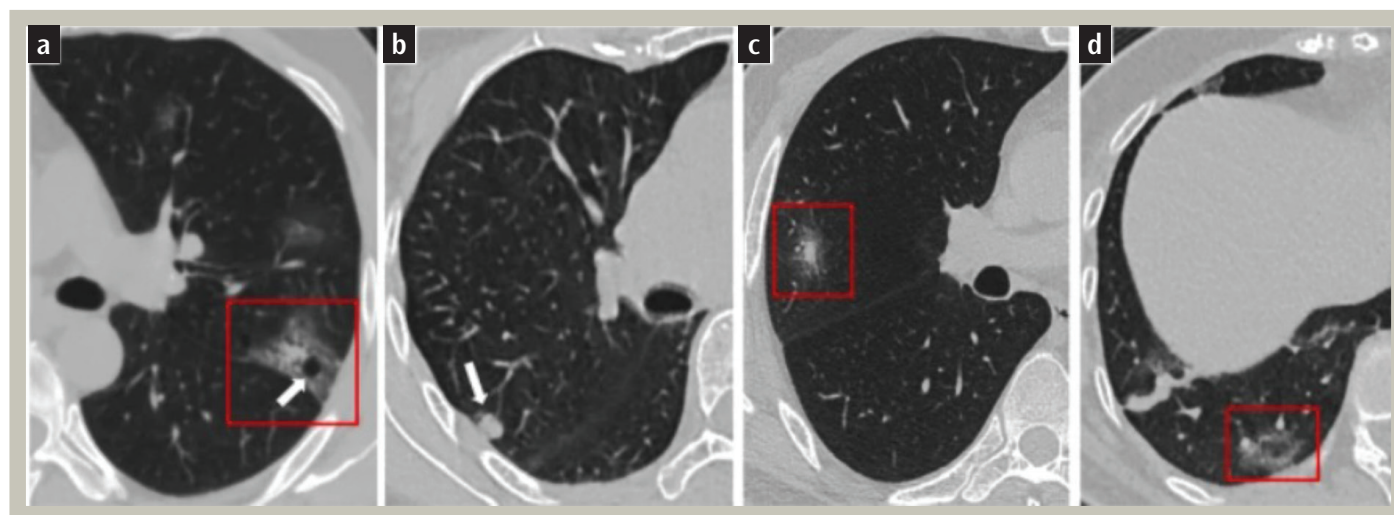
a) CT scan showing a patchy GGO (red frame) with an air bubble sign (white arrow) in the apicoposterior segment of the upper left lobe. b) An irregular nodule (white arrow). c) A solid nodule surrounded by a ground glass halo (red frame). d) A reversed halo sign (red frame) (9)
